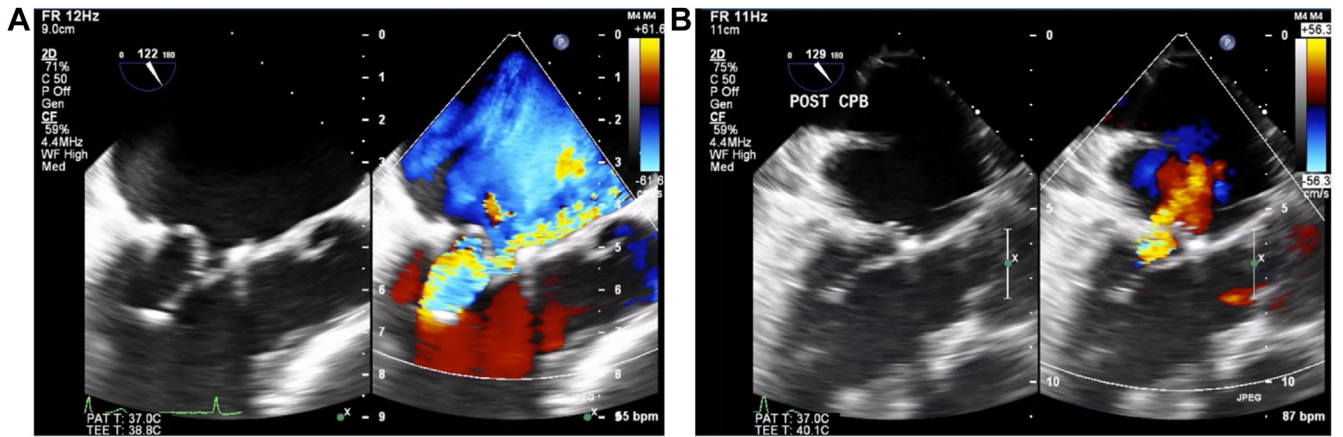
(A) Pre-CPB transesophageal echocardiography demonstrating prolapsing posterior leaflet and severe MR. (B) Post-CPB transesophageal echocardiography demonstrating repaired mitral valve with mild MR. CPB, cardiopulmonary bypass; MR, mitral regurgitation
